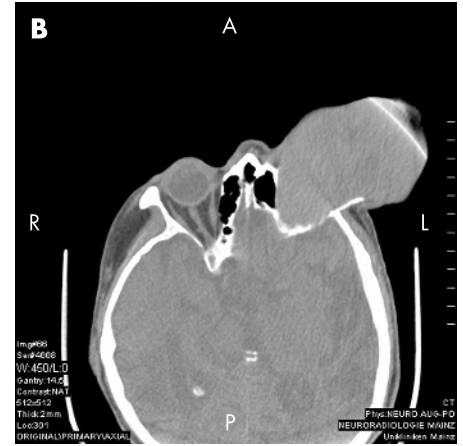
(A) Preoperative photograph of patient with a fist-sized tumour of the left orbit. (B) Computed tomography showing a homogeneous orbital mass. Informed consent was obtained for publication of this figure.
